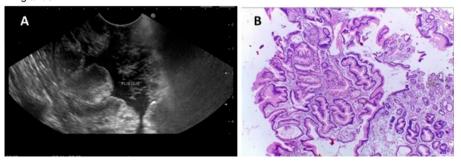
A: Endoscopic ultrasonography shows thickness of gastric wall and preservation of five-layered structure. B: Hyperplasia of the foveolar component and tortuous and dilated glands
